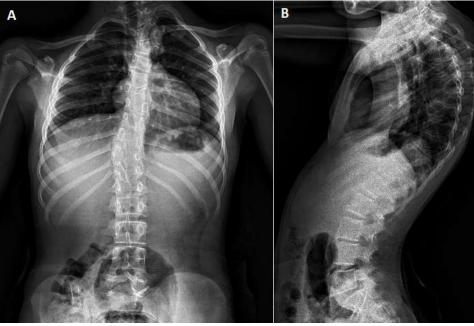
anteroposterior (A) and lateral (B) x-ray images of twin 1
